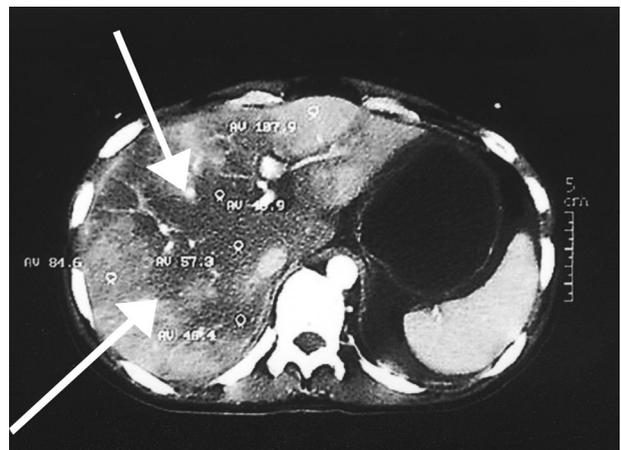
Computed tomography scan of the abdomen in a patient with acute fatty liver of pregnancy. The arrows are pointing toward the changes in density in liver tissues (left side) compared with homogenous texture in spleen tissue (right side).
